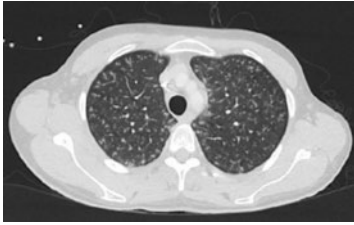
Chest CT scan: multiple pulmonary nodules.
